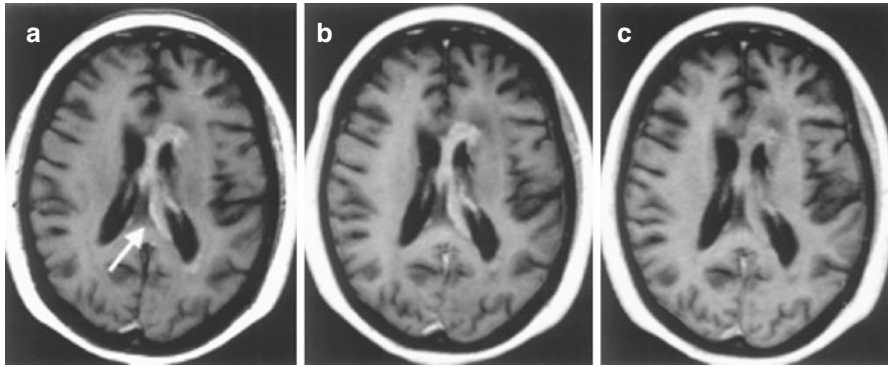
t1 axial MRI showing primary CNS lymphoma
